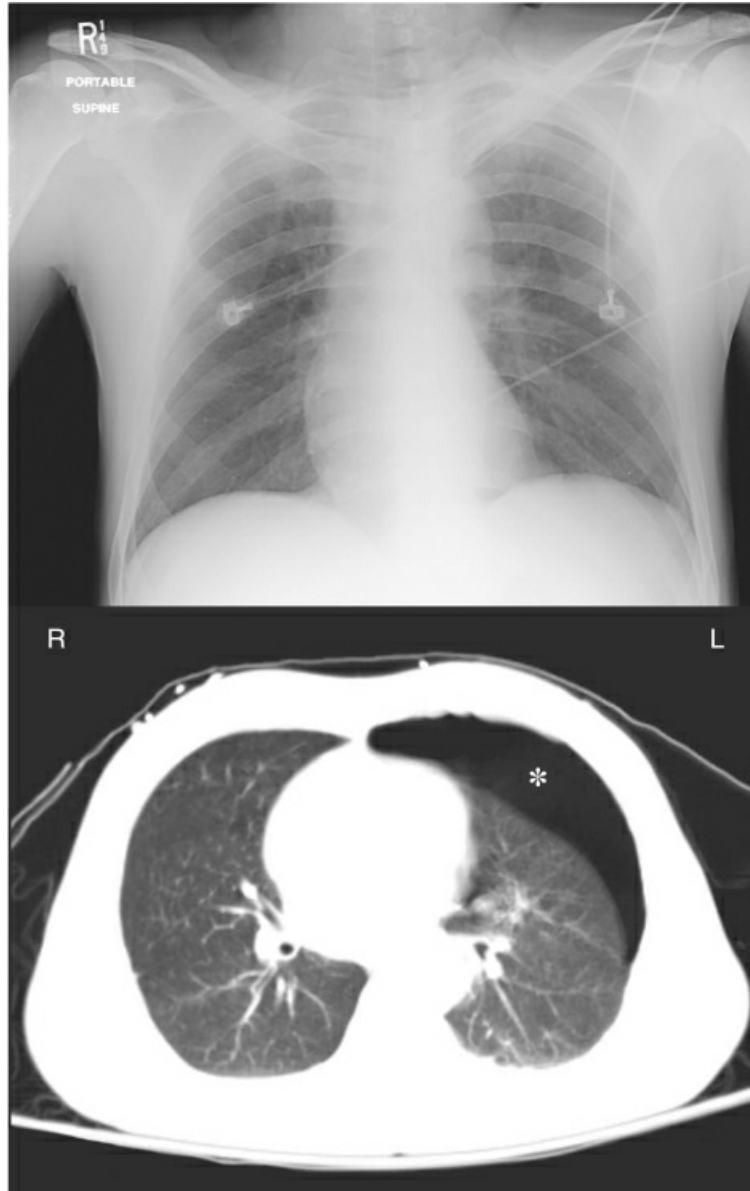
A portable chest x-ray and CT image of the thorax in a young male with blunt trauma to the chest. An anterior pneumothorax is evident on the CT image (indicated by the asterisk) but is not apparent on the portable chest x-ray.
